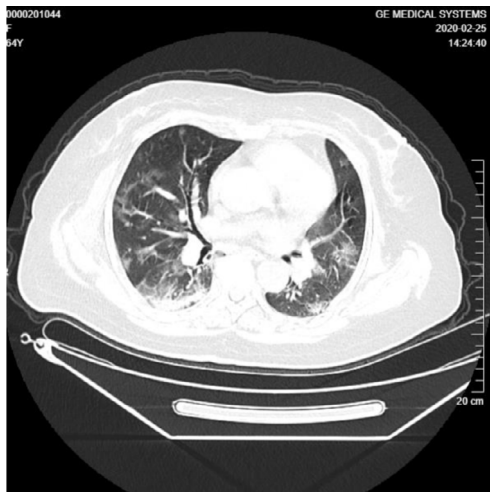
Lung CT image when the patient was admitted.
